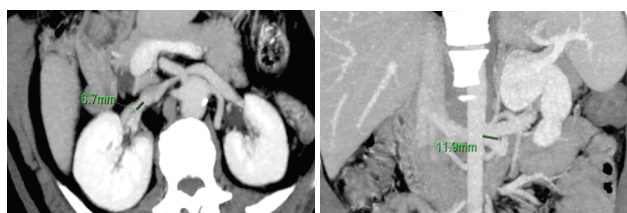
Curved axial and coronal reformatted CT images showing late venous confluences on right (a) and left (b) kidney.
